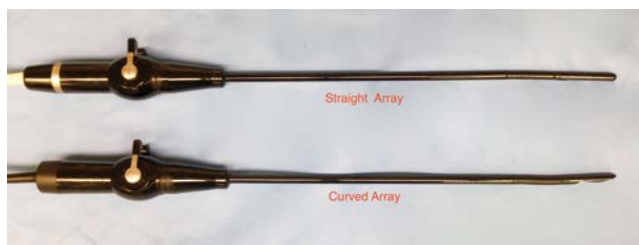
Laparoscopic ultrasound transducers.
